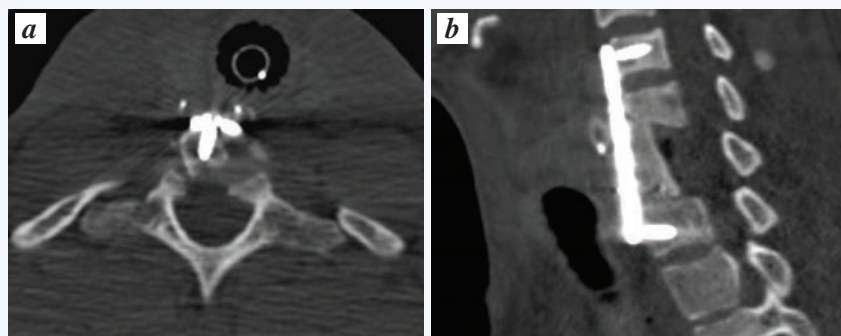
Reconstruction of non-contrast CT of the cervical spine (an anterior fixation): a – axial; b – sagittal.
